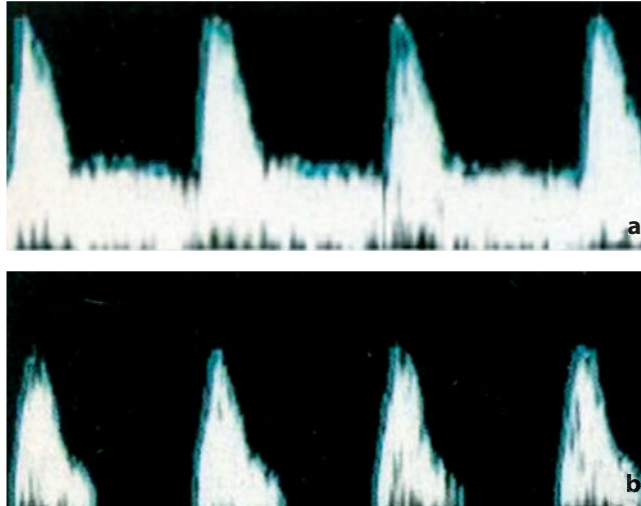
Doppler traces. a The image shows the normal trace of a testicular artery. The diastolic component is clearly visible, a typical finding in low-resistance vessels. b In the trace of the deferential artery the diastolic component is clearly absent
